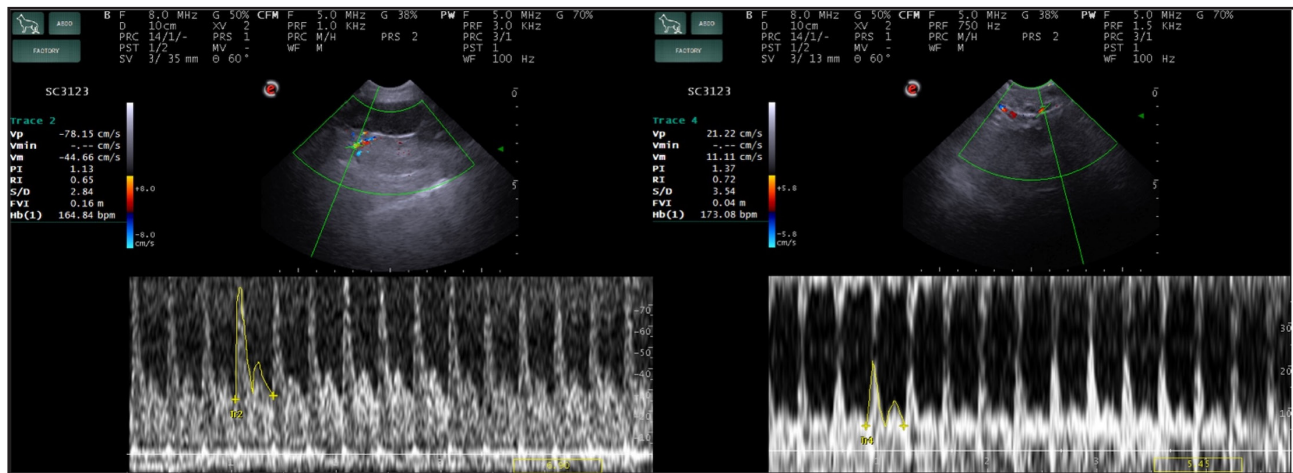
Color Doppler images of the primary mass at room temperature obtained Pre-T and Post-T solution infiltration, demonstrating changes in vascularization.
